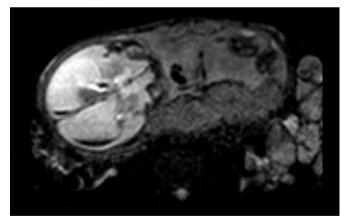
T1-weighted sagittal magnetic resonance image of fetus at 27 weeks 2 days.
